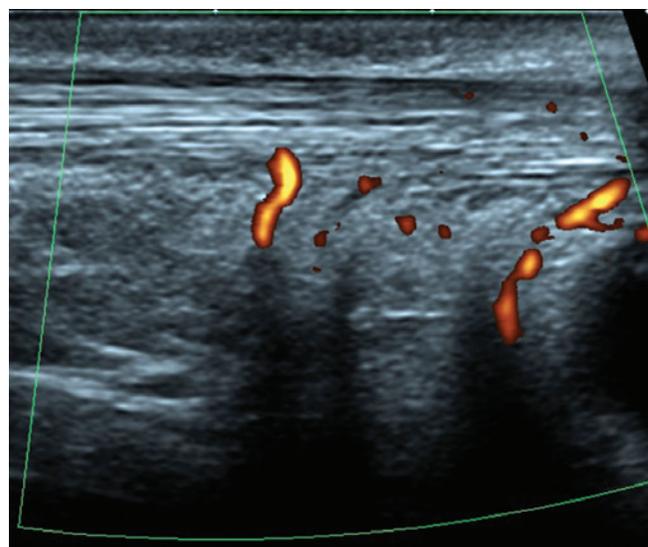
Ultrasound, increased echogenicity and vascularization of the Kager's fat pad
